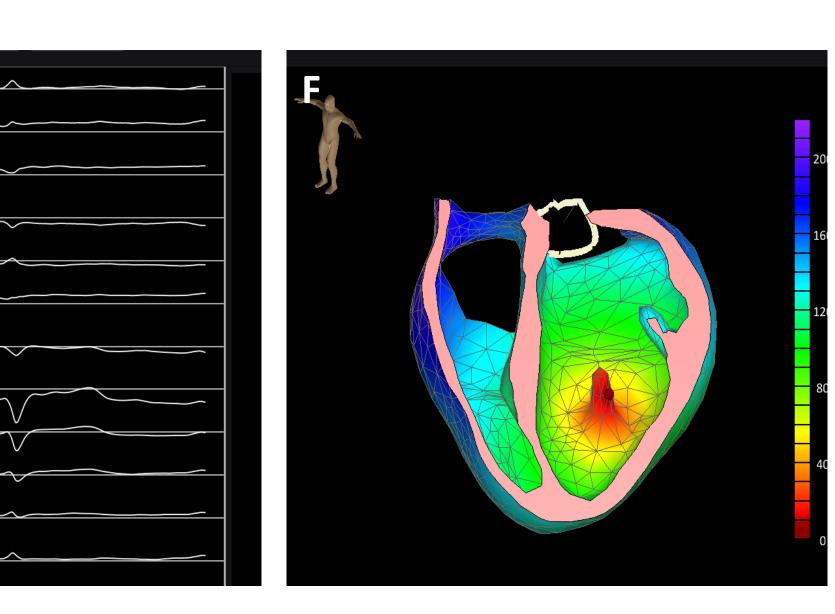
VIVO Model. (A) VIVO model constructed from MRI. (B) Segmented VIVO model with a leads merged to the patients' torso. (D) Pulling in PVC morphology. (E) VIVO analysis of the PVC
